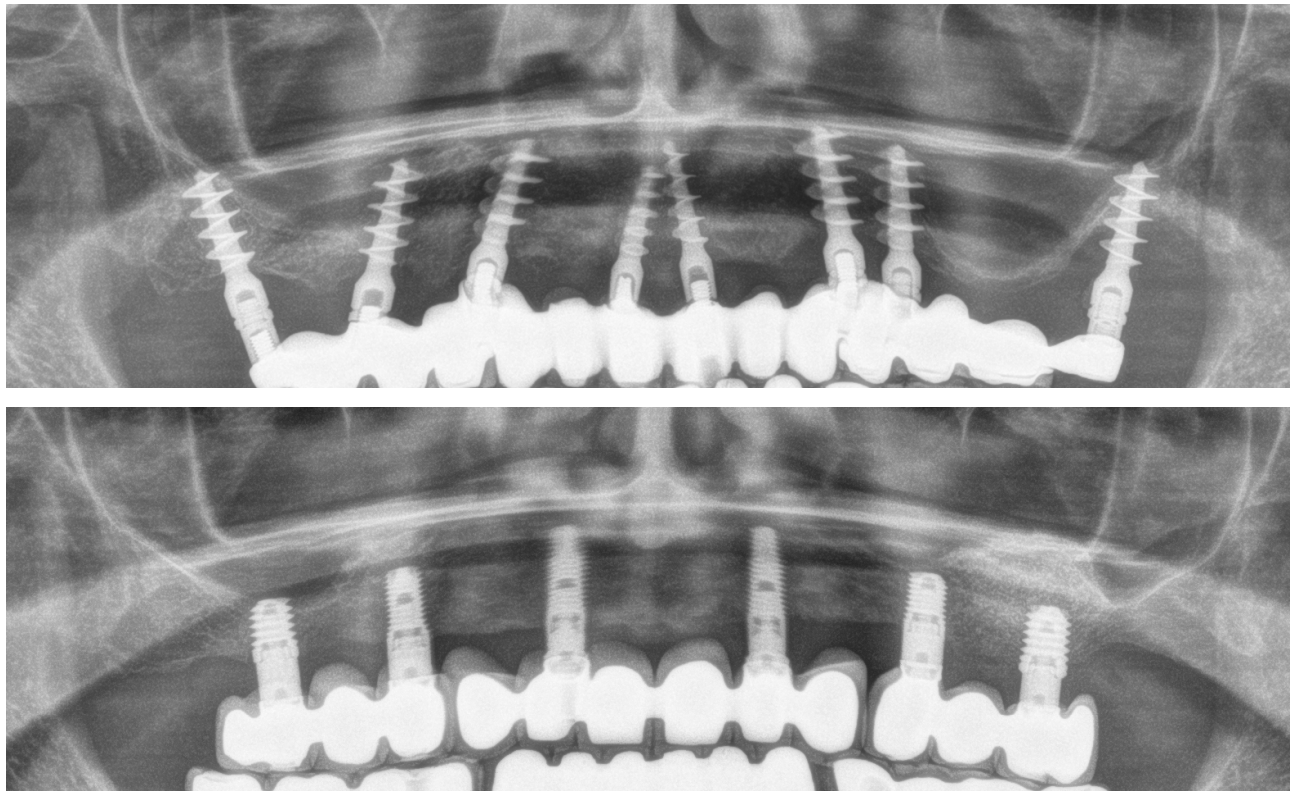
Final radiographic image of the rehabilitation placed after its elaboration. We can see how it has been divided into three sections to favor the biomechanics of the set and the dispersion of the tensions in the surrounding bone of the implants during mastication.
